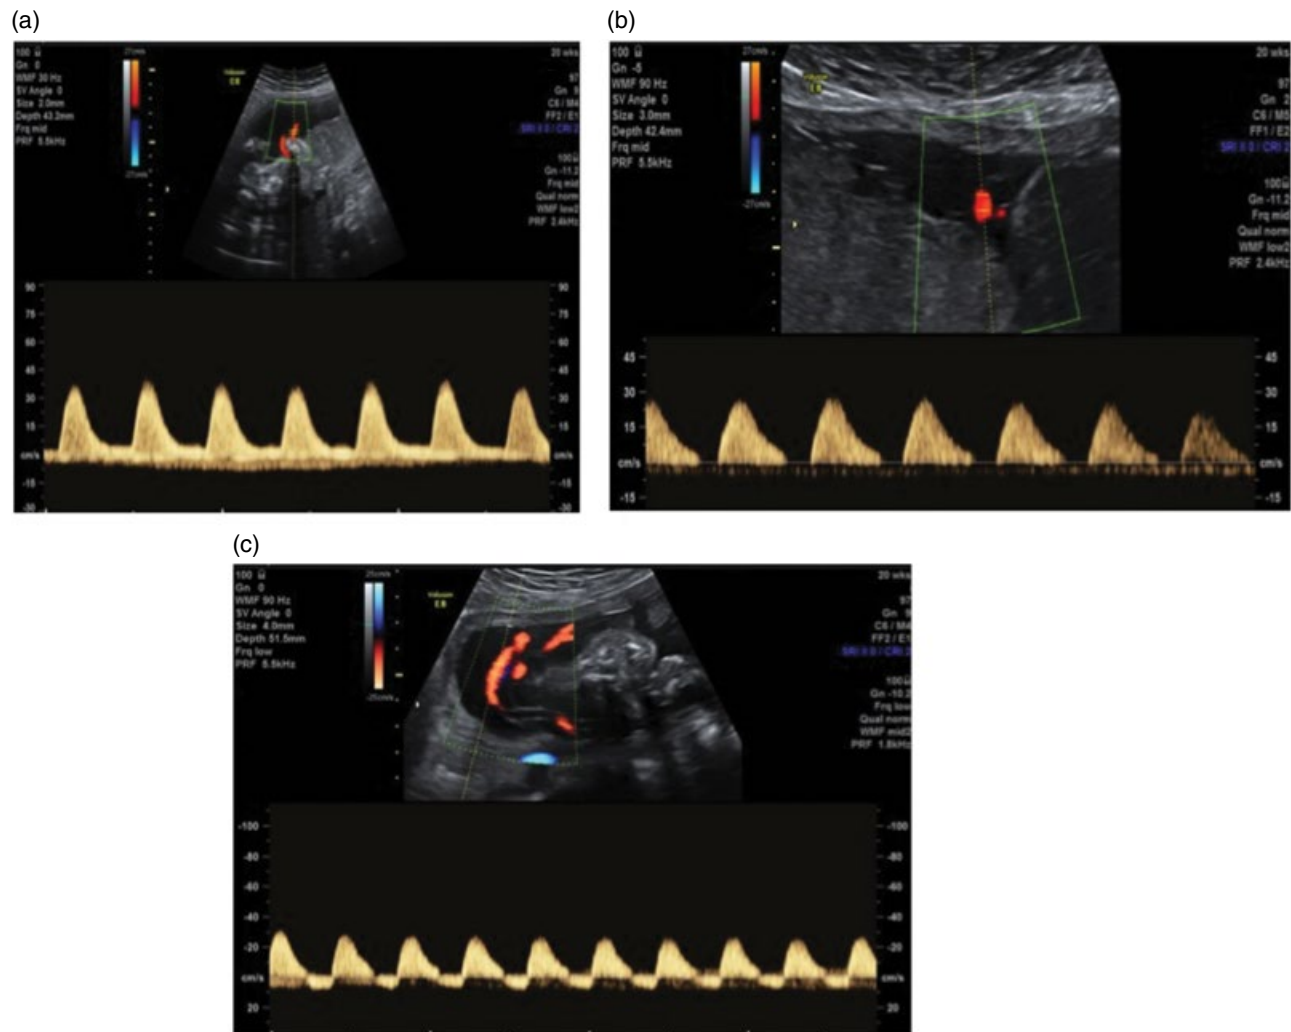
Umbilical artery Doppler waveforms: (a) normal; (b) absent end-diastolic flow; (c) reversed end-diastolic flow.
